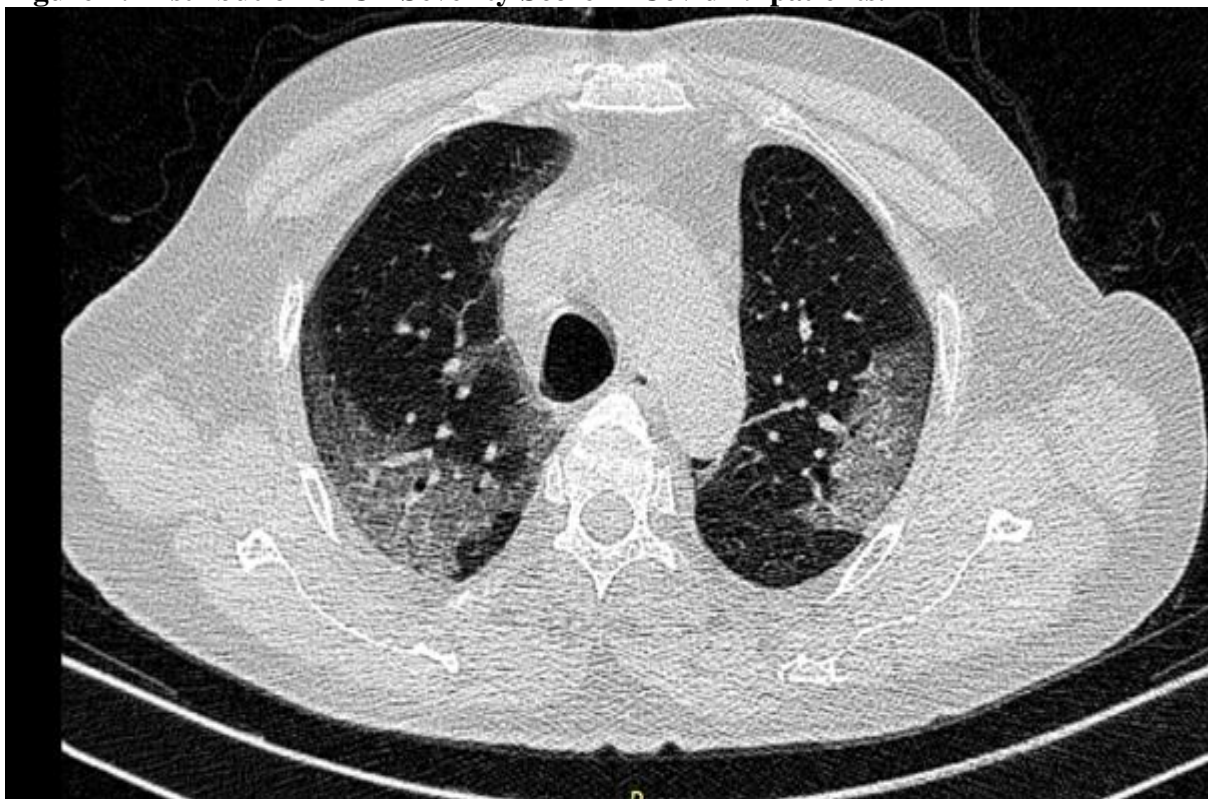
CT chest showing ground glass opacities
